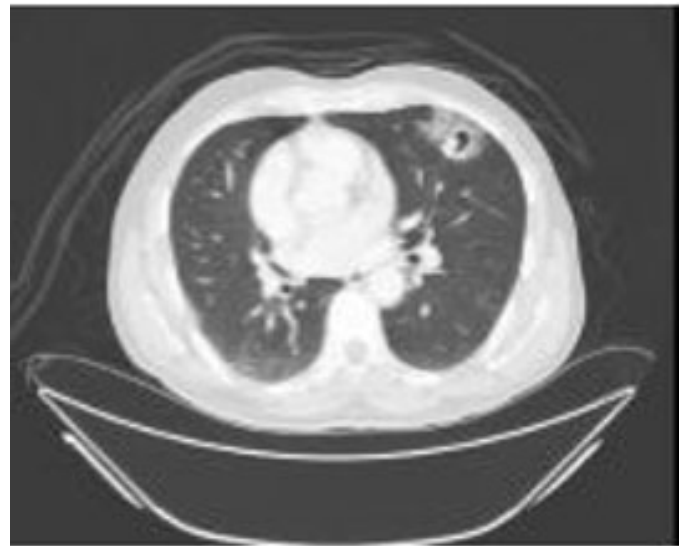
Post-operative CT axial section (lung window) showing cavitary nodule and ground-glass appearance with interlobular septal thickening.
